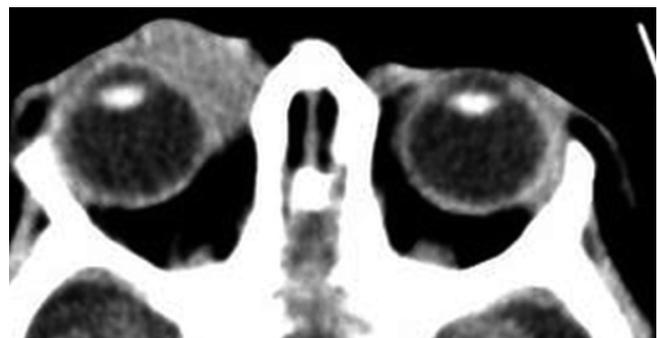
CT finding before treatment
